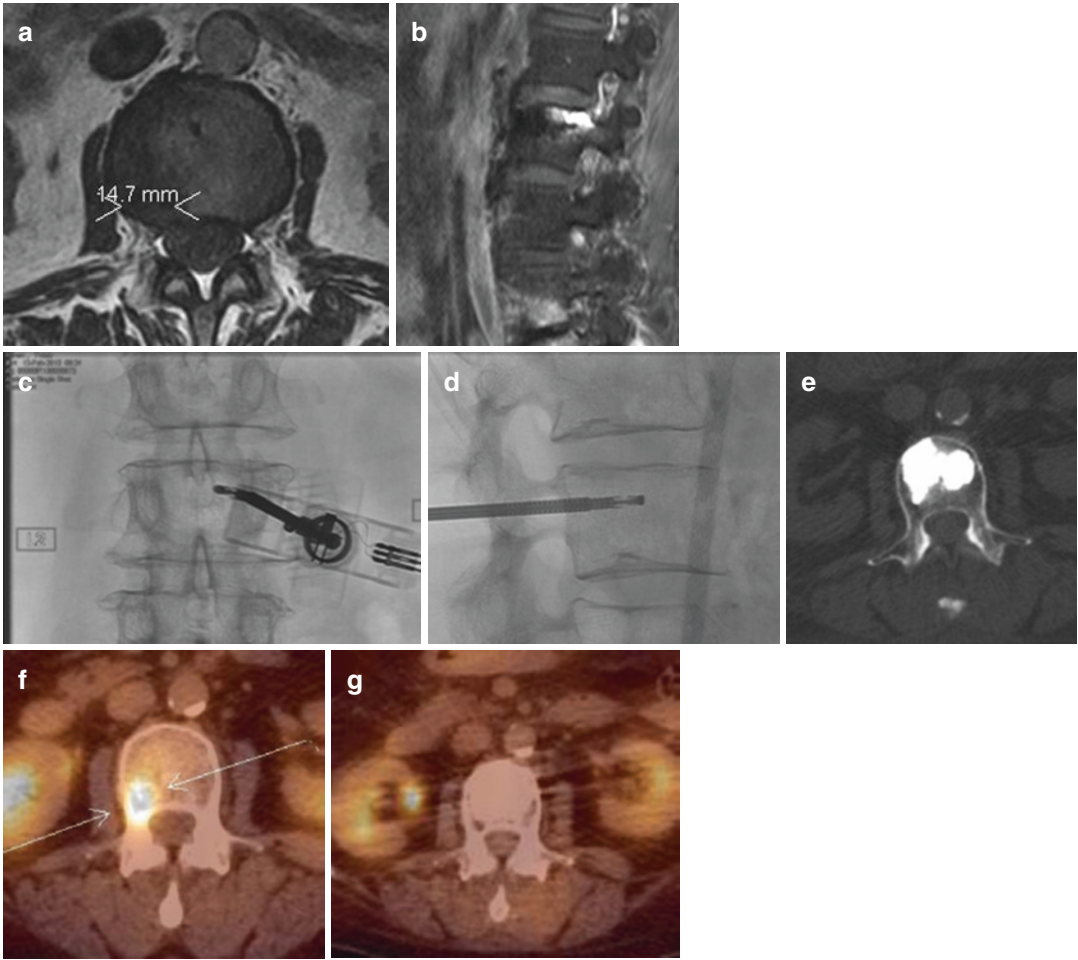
Posteriorly located L2 metastatic breast cancer in a 76-year-old woman. (a) is an axial T1-weighted image showing a right posteriorly located metastatic lesion. (b) parasagittal T1-weighted image with fat suppression, again showing the enhancing posterior superior lesion. (c) and (d) are AP (c) and Lateral (d) fluoroscopic images showing adequate placement of the STAR device
